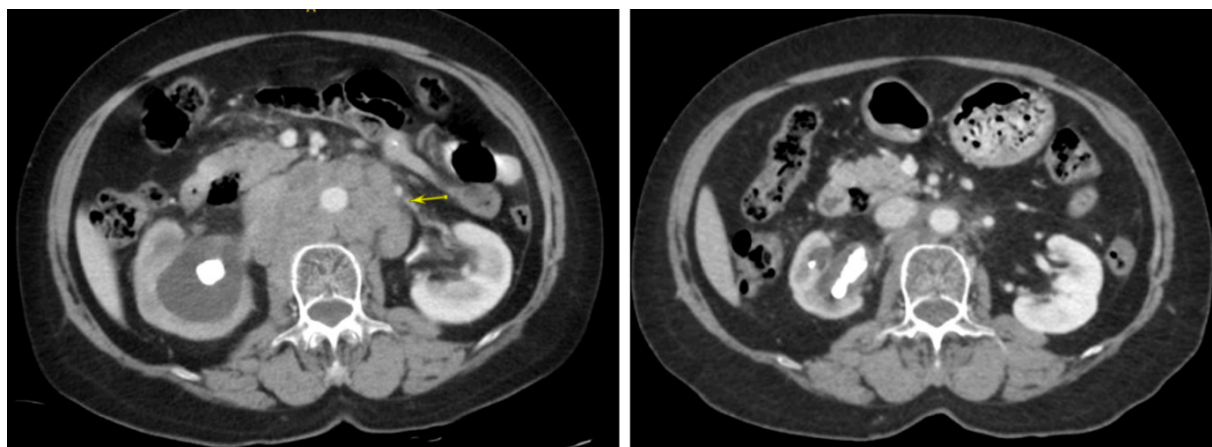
CT scan of the abdomen before and after Temozolomide treatment
